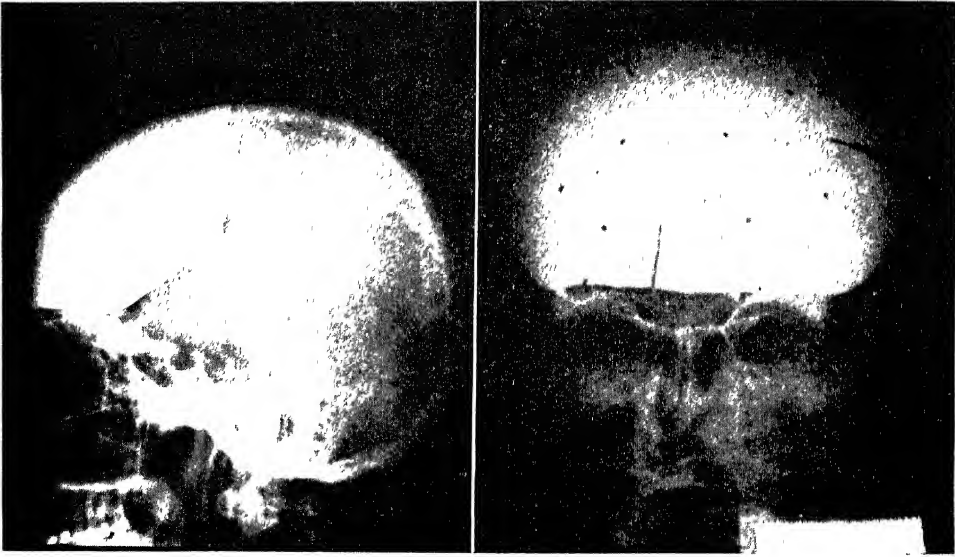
G M. Postoperative x-ray anteroposterior and lateral views, May 17, 1944, showing tantalum plate firmly fixed in position (Schnitker, M. D. and McCarthy, M. D.: Surgery 18: 94 (July) 1945.)
